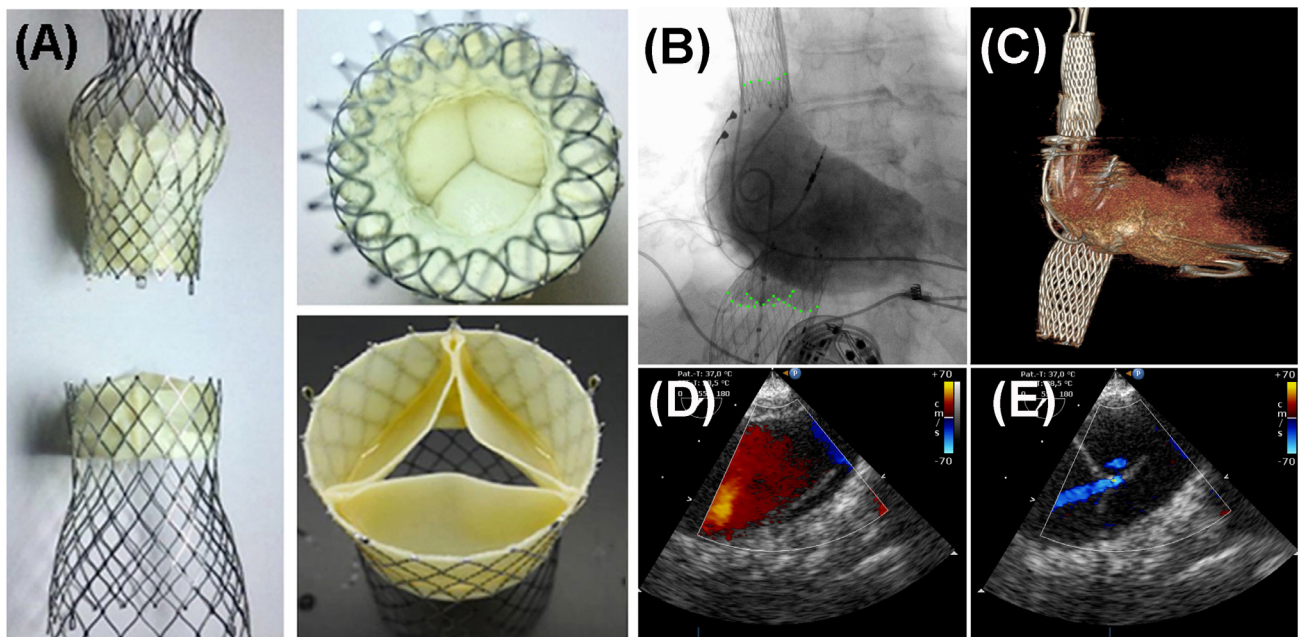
Caval Valve Implantation (CAVI) using balloon-expandable valves (SEV). (A) The TricValve-SEV, an investigational device with two designated valves for SVC and IVC position has been used for CAVI. (B, D, E) An angiogram of the right atrium and transesophageal echo demonstrates function of both valves. (C) Position of both valves is visualized by CT.
